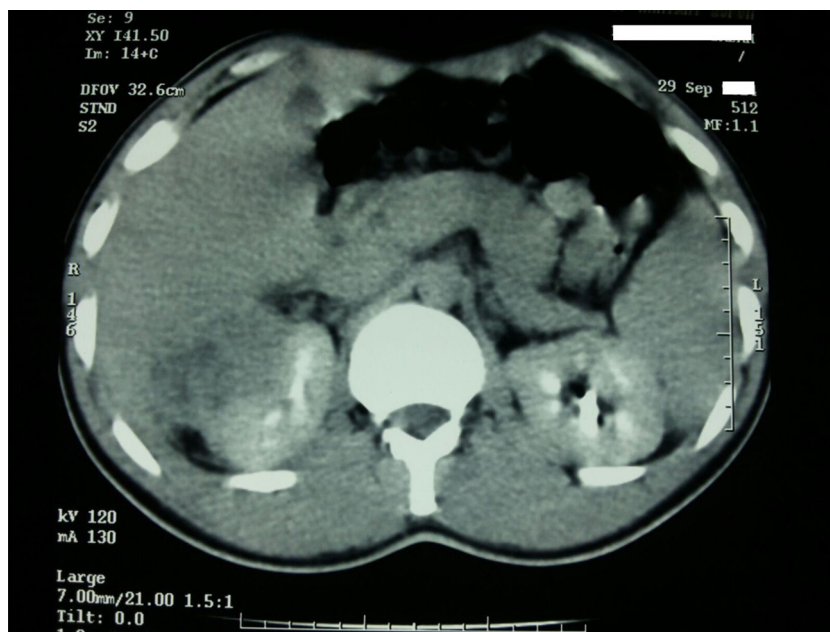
A contrast-enhanced CT axial view of the abdomen showing the extent of the upper pole tumor of the right kidney to the calyceal tract.
